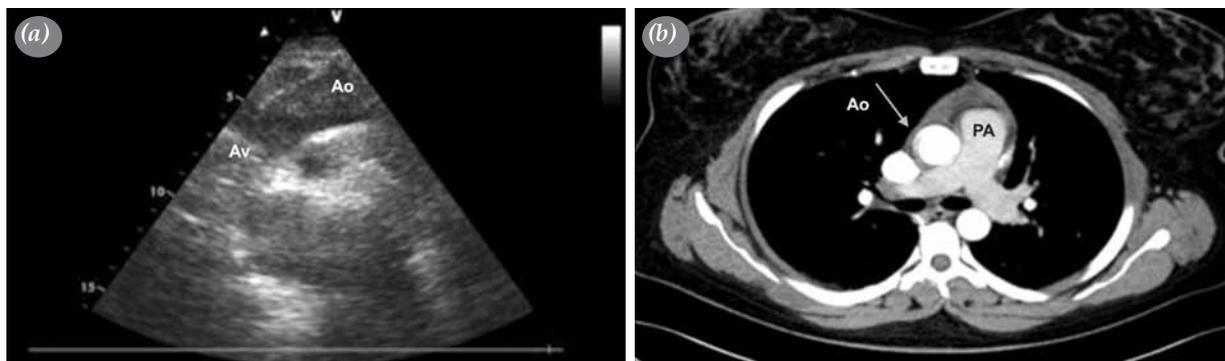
(a) Transesophageal echocardiographic view showing the aortic flap (arrow) and (b) contrast-enhanced thoracic computed tomography suggesting the presence of a suspicious intimal flap in the ascending aorta. Ao: Ascending aorta; Av: Aortic valve; PA: Pulmonary artery.
